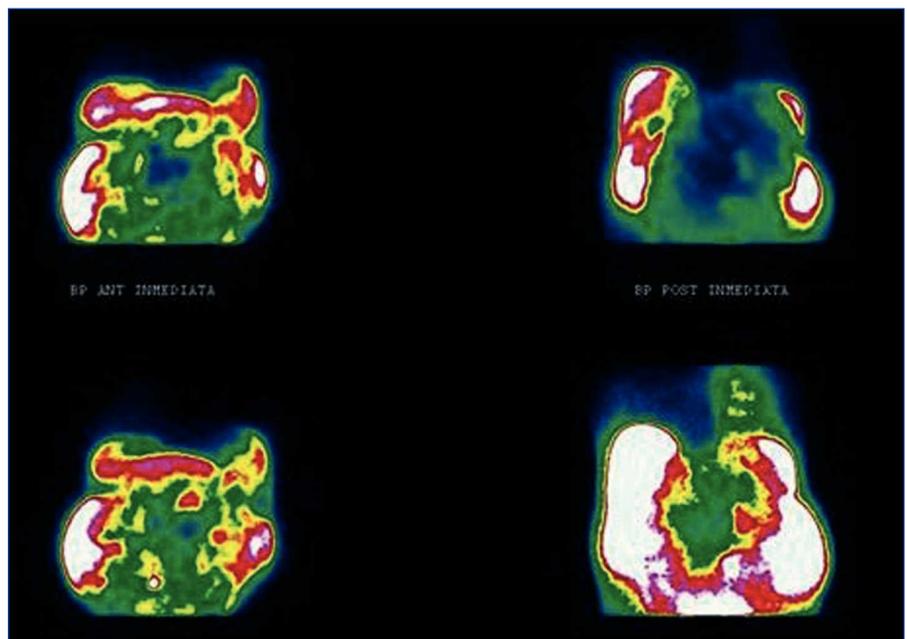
Peritoneal scintigraphy with 99mTc-MAA. Anterior and posterior views in supine position showing the tracer passing to the right hemithorax.
